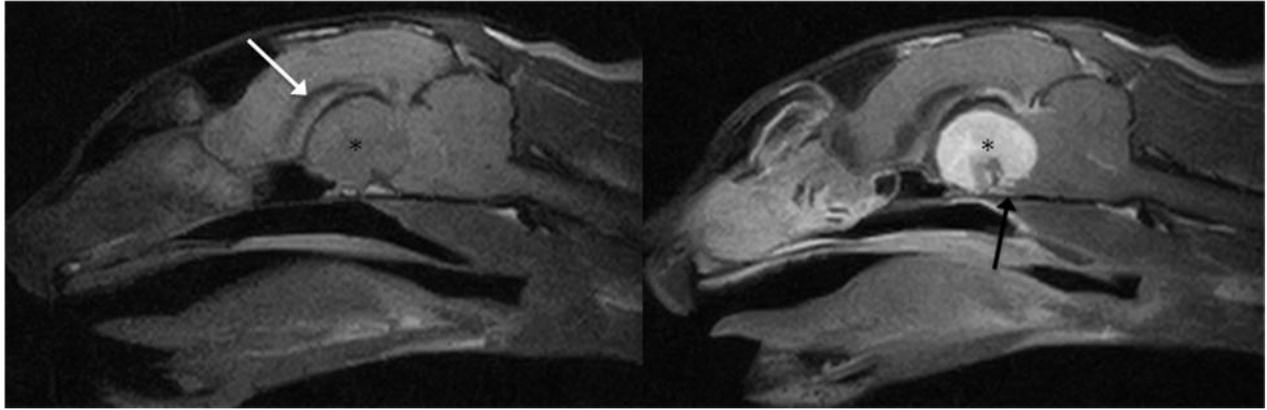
Mid-sagittal T1-weighted pre-contrast (left) and post-contrast (right) images of the brain. A mild, hypointense rounded mass (*) compressing the lateral ventricles (white arrow) is visible. An intense homogenous contrast enhancement is visible within this mass (*). Enhancement of the meninges (=dural tail) can also be seen (black arrow).
